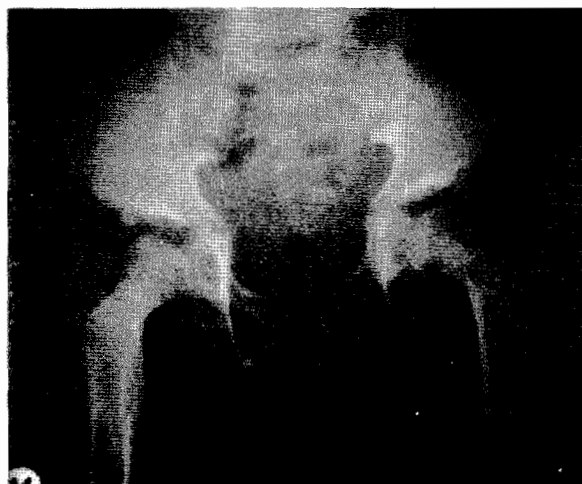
Plain radiograph of the iliac bone showing an unusual tapering towards the acetabula with fusion of the sacro-iliac joint. The acetabula fossae bilaterally is sclerosed and shallow with irregular protuberances.
